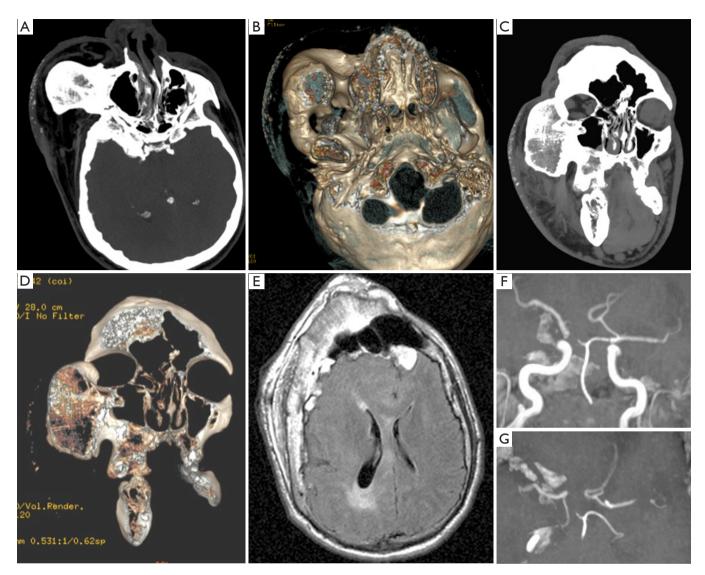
Patient 4 (*Table 1*): axial MIP (A) and volume rendering (B) and coronal MIP (C) and volume rendering (D) CT scan of the brain; axial T2-flair (E) magnetic resonance image of the brain; and brain MRA (F,G). Note the massive hypertrophy of the right skull with dotted calcifications of the soft tissues of the face (A-D); the complex right hemispheric ventricular and cortical malformation (E) and the anatomical variants of the inner circle with right A1 and P1 arteries hypoplasia. CT, computerised tomography.
